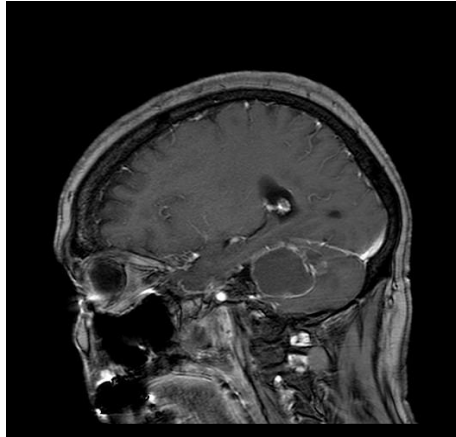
Contrasted MRI done prior to final surgery
